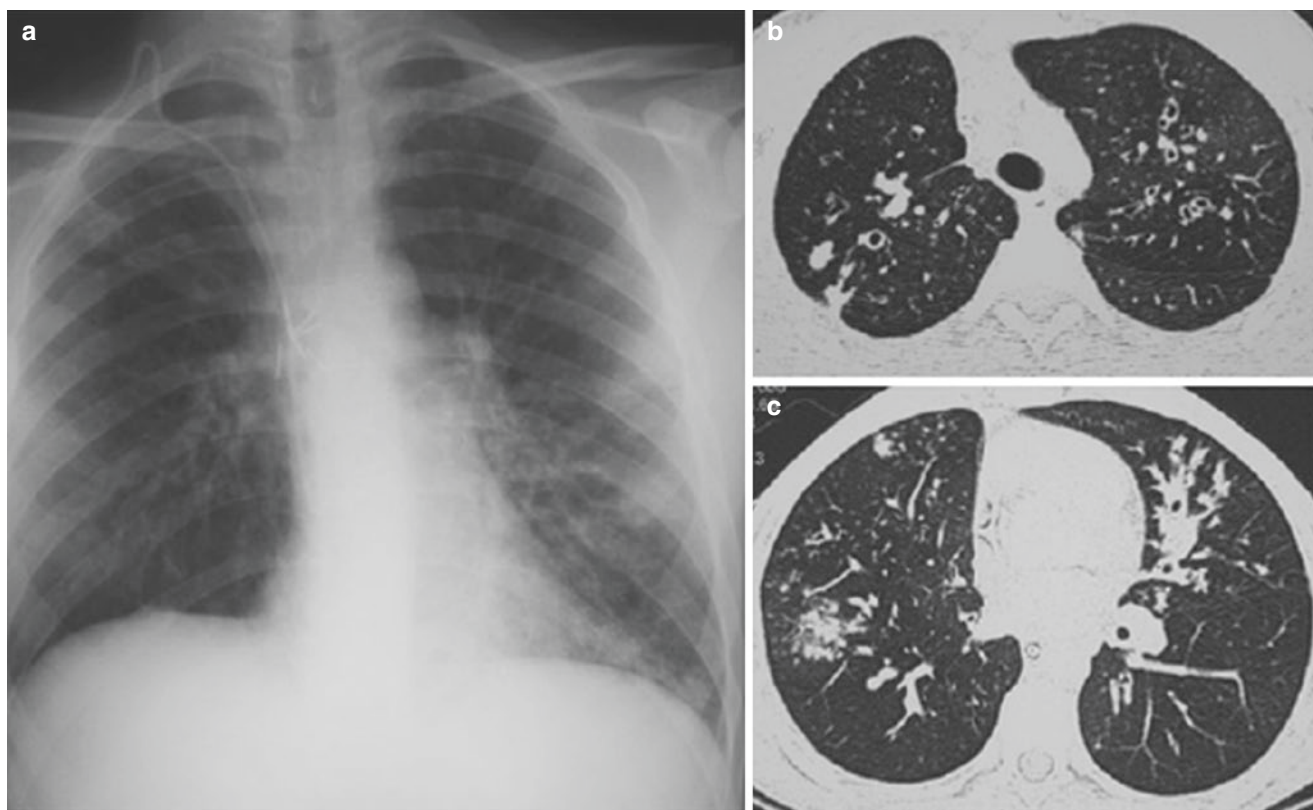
Sixteen-year-old boy with allergic bronchopulmonary aspergillosis (ABPA). (a) Chest X-ray shows ill-defined patchy opacification in the left lower and right upper lobes. (b) CT chest shows moderate to severe bronchial wall thickening with bronchiectasis. (c) On the left
